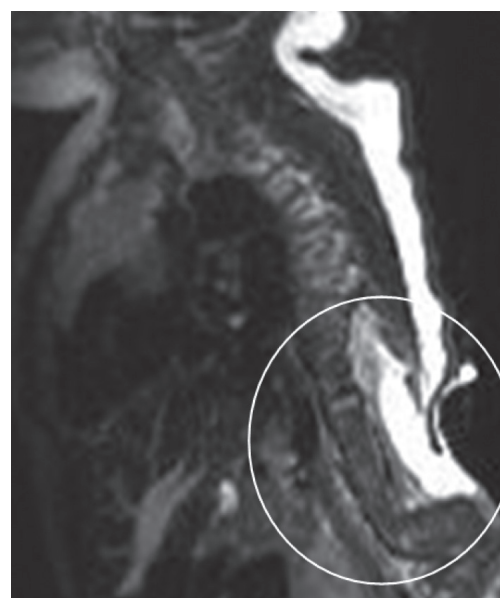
The sagittal unenhanced T1-weighted image of the spine shows thoracolumbar spina bifida cystica with the sac filled with cerebrospinal fluid and neural placode of the “normal” hemicord which correspond to hemimyelomeningocele.
